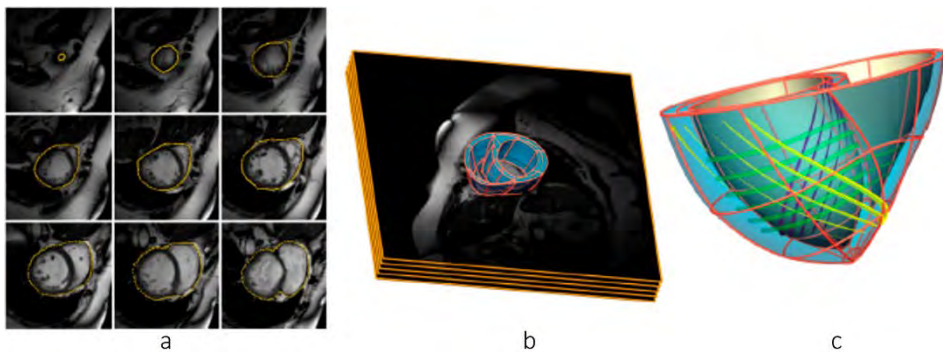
Patient-specific bi-ventricular model. (a) Set of *in-vivo* cardiac MRI slices showing manually segmented epicardial contour. (b) 3D cardiac model overlaid on the MRI stack. (c) Finite-element mesh with tri-cubic Hermite elements showing lines corresponding to the main direction of cardiac fibre orientation at epicardial (yellow), mid-wall (green) and endocardial (purple) level. Reproduced from (Niederer et al., 2009)
